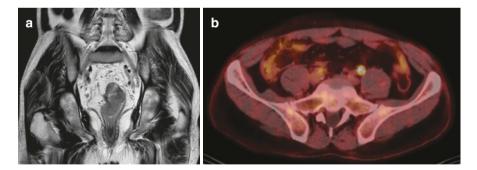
A 48-year-old male patient with biopsy-proven adenocarcinoma of the rectum. (a) T2W coronal MR image demonstrates a polypoid mass in the rectum showing no mesorectal infiltration. The perirectal fat is homogenous and the hypointense line representing the muscular layer is intact corresponding to T2 stage. There are a few small lymph nodes inside the mesorectal fascia with no suspicious features of metastases. (b) FDG PET-CT demonstrates a high tracer uptake in the lymph node adjacent to the left iliopsoas muscle which is considered as metastatic. It is not obvious in CT or MR images. As this lymph node is outside the mesorectal fascia and circumferential resection margin, PET-CT plays an important role in the management of the patient because the lymph node should be resected and included in the radiation area to prevent recurrence
